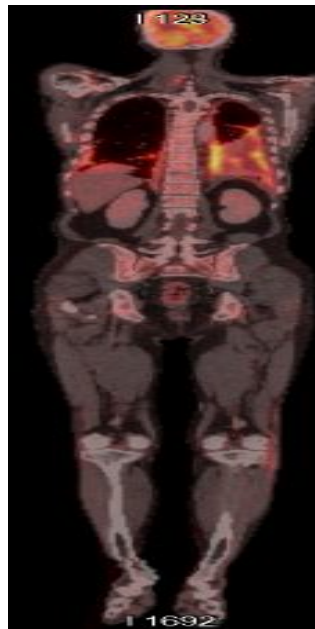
PET CT of the whole body
